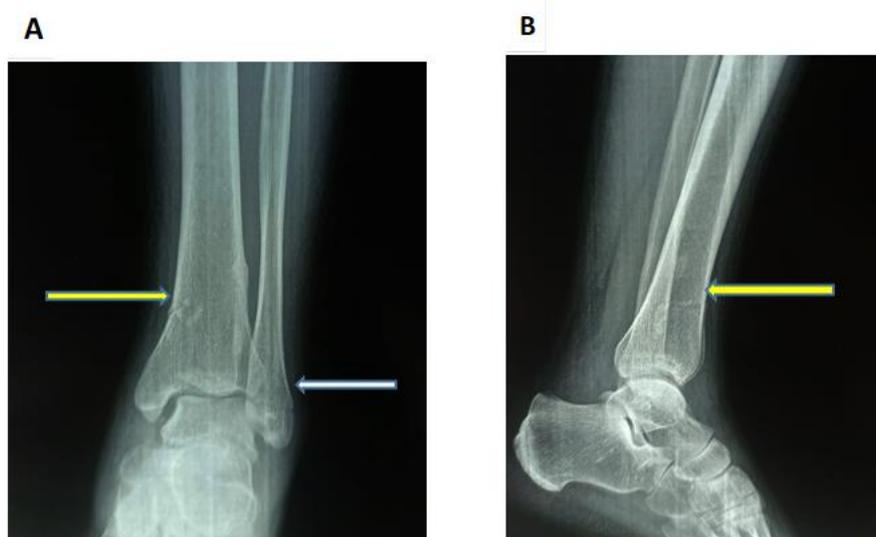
Standard radiograph of the left ankle; yellow arrow showing pilon fracture and white arrow showing lateral malleolus fracture
